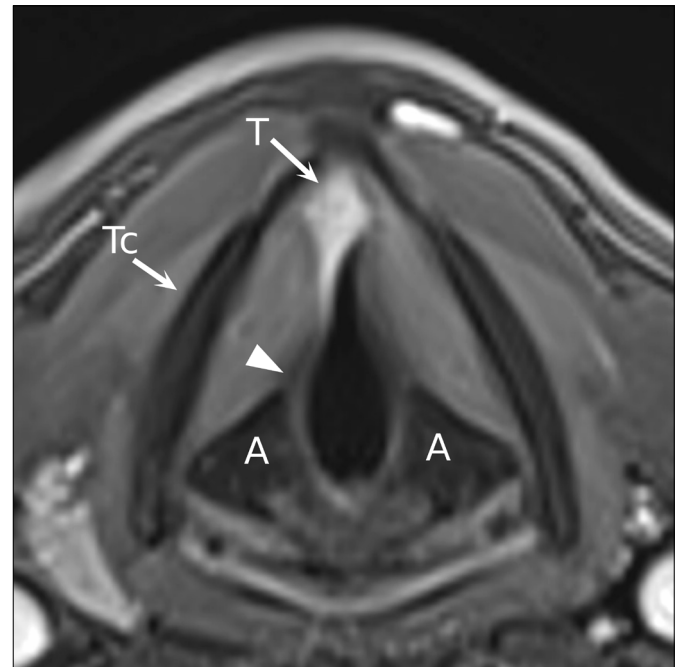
MRI of a small-volume cT1b confined to the horizontal plane of the AC, without cartilage invasion and no trans-AC vertical extension. T: tumour; Tc: thyroid cartilage; A: arytenoids; white arrowhead, vocal process of the right arytenoid.
